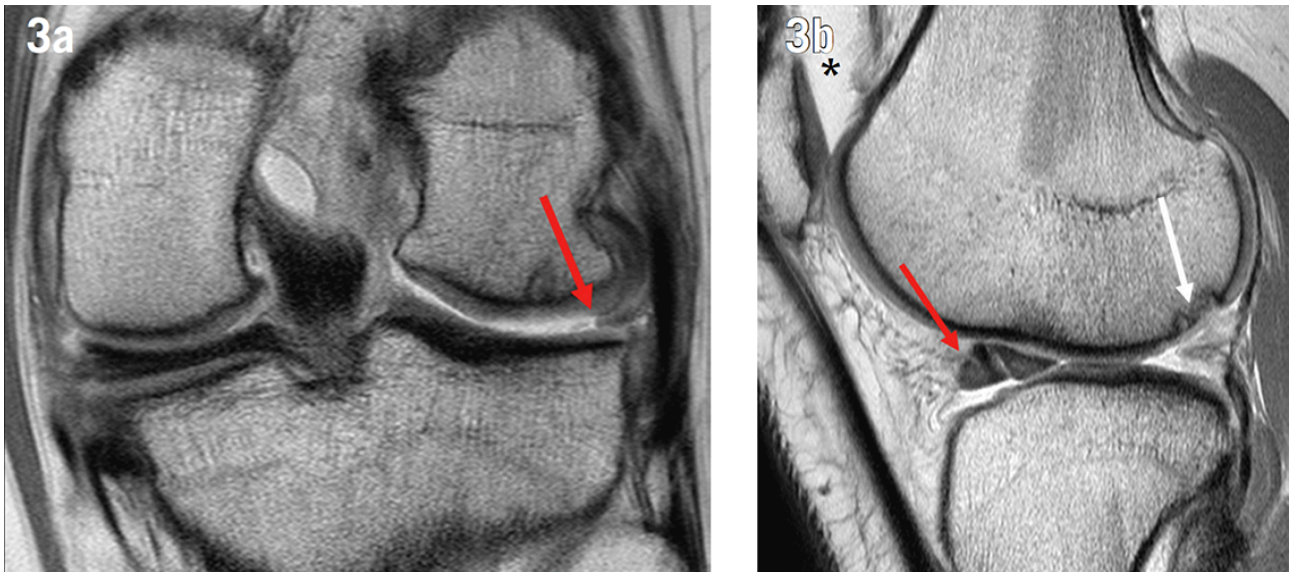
28-year-old football player with injury 6 months earlier. a) Coronal intermediate-weighted MRI shows avulsion of the posterior root and posterior horn of the lateral meniscus (arrow). b) Sagittal intermediate-weighted MRI confirms the findings in a) and shows that the posterior horn is not lying in anteriorly to the anterior horn (red arrow). There is a large focal cartilage defect at the central weight bearing lateral femur with subchondral bone marrow cystic changes (white arrow). There is also a large joint effusion (star). Adapted with permission from Nielsen et al. (81)
